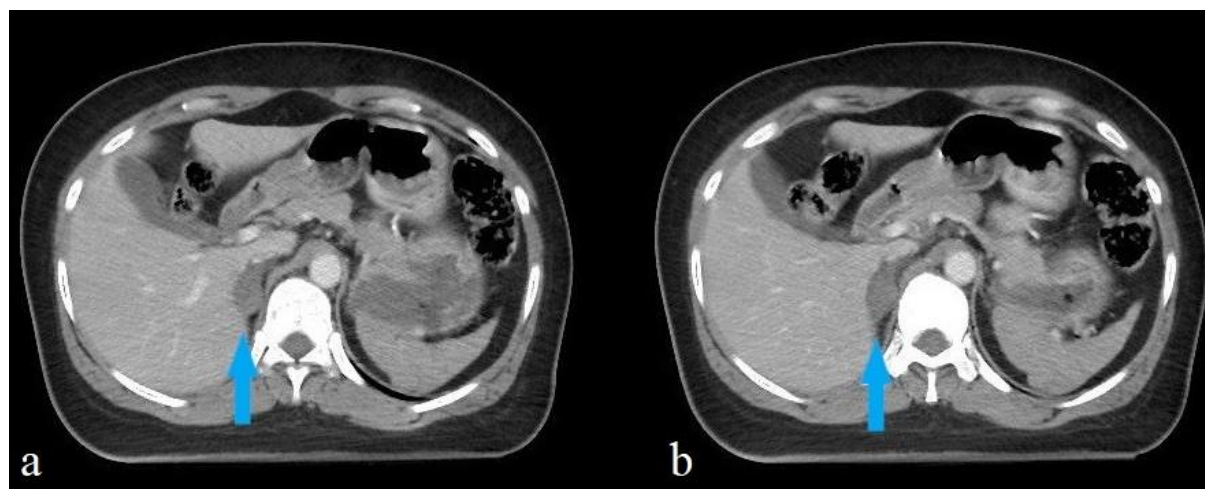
(a), (b): Abdominal axial contrast-enhanced computed tomography sections show hematoma in the right adrenal gland (blue arrow).
